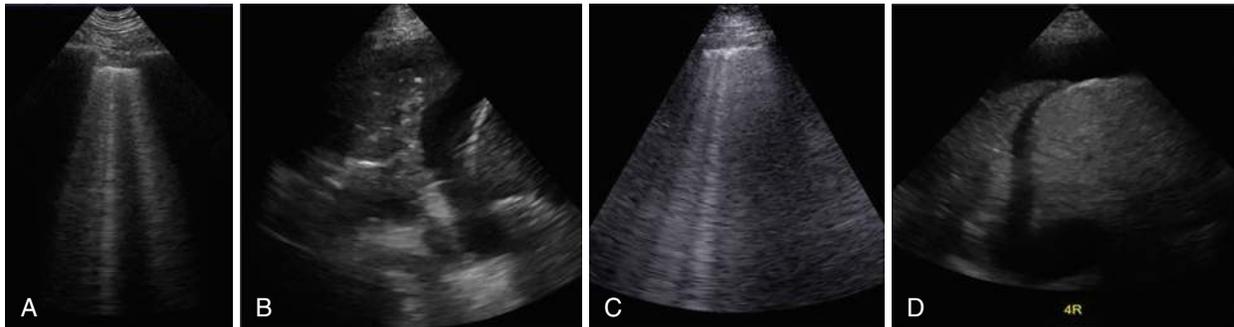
Bedside Lung Ultrasound Images Suggestive of acute respiratory distress syndrome (ARDS). Lung ultrasound is an adjunct to the clinical examination for the diagnosis of ARDS. ARDS ultrasonic images reflect nonhomogeneous lung disease by combining normal A lines (spared areas) with the B pattern, and subpleural and translobar consolidation characterized by abolished lung sliding and irregular and thickened pleural lines in at least two regions. (A) Nonhomogeneous B lines; (B) thickened irregular pleura, (C and D) consolidative pattern (“C” profile).
